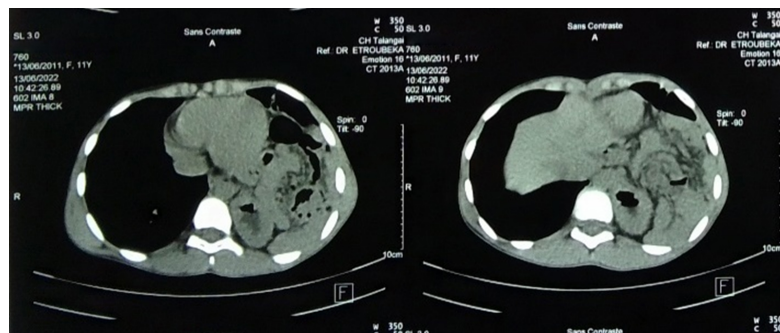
CT scan without injection (thoracic floor): A hernia of the abdominal viscera that takes up almost the whole of the left lung.
